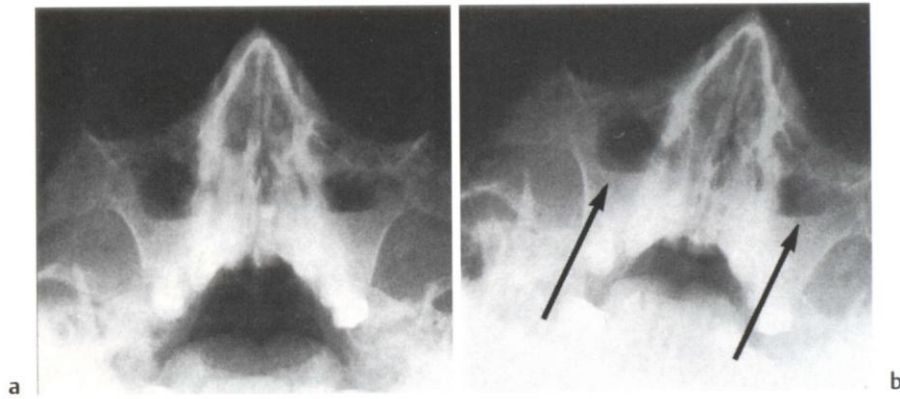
Maxillary sinus radiographs. In acute and chronic maxillary sinusitis, a fluid level may be seen on radiography. A tilted view is taken to confirm the presence of fluid (b, arrows). A thickened or rather “straight” mucous membrane may look like a fluid level, as may a bony shadow if the radiograph is wrongly angled.
